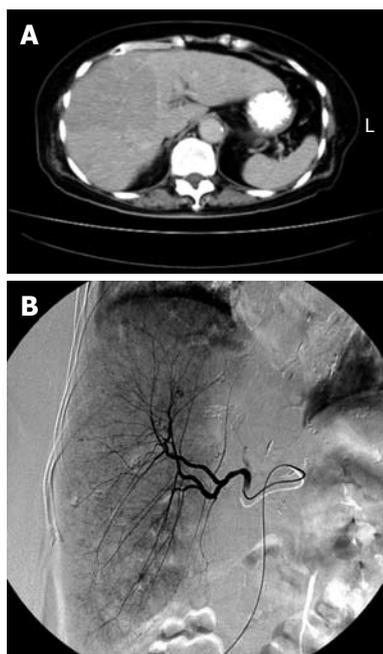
Computed tomography scan obtained before TACE showed a large HCC over the right lobe (A), and TACE revealed hypervascularization of the tumor (B).
